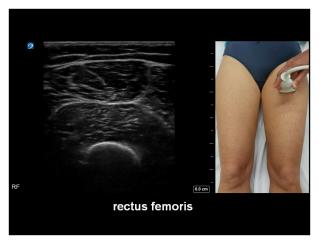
Muscle ultrasound of the rectus femoris, as recorded at 1/2 of the distance between the anterior superior iliac spine and the upper pole of the patella.
